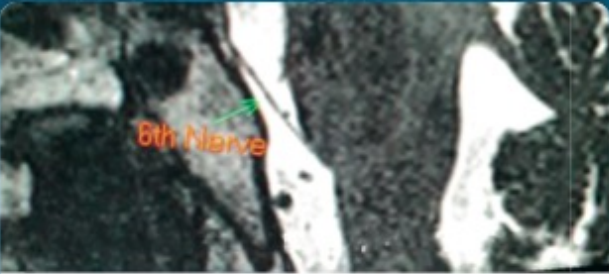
High resolution T2W MRI sagittal
